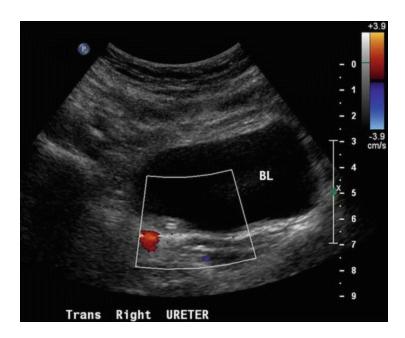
Color Doppler US of the right distal ureter demonstrates an echogenic stone at the ureterovesicle junction
